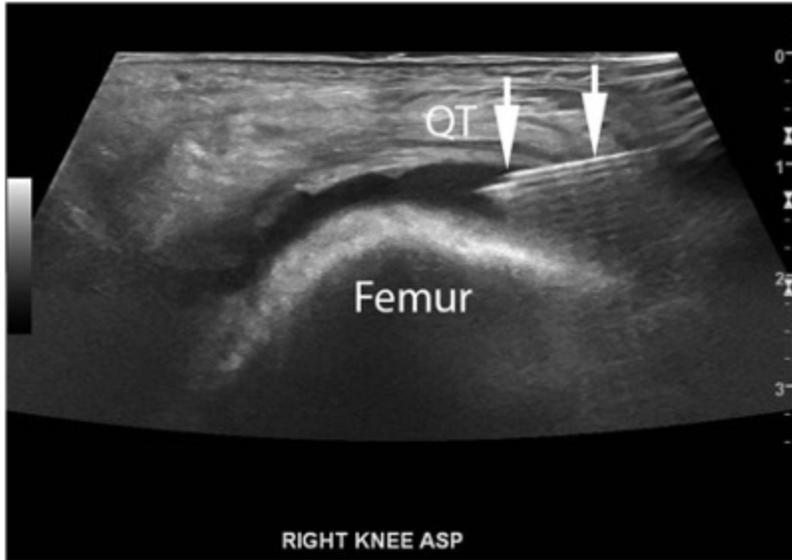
Aspiration of knee joint under ultrasound guidance. Lateral transverse approach into the suprapatellar recess. The short 20-gauge needle (straight arrows) is directed under the quadriceps tendon (QT) into the lateral patellar recess which contains fluid.
